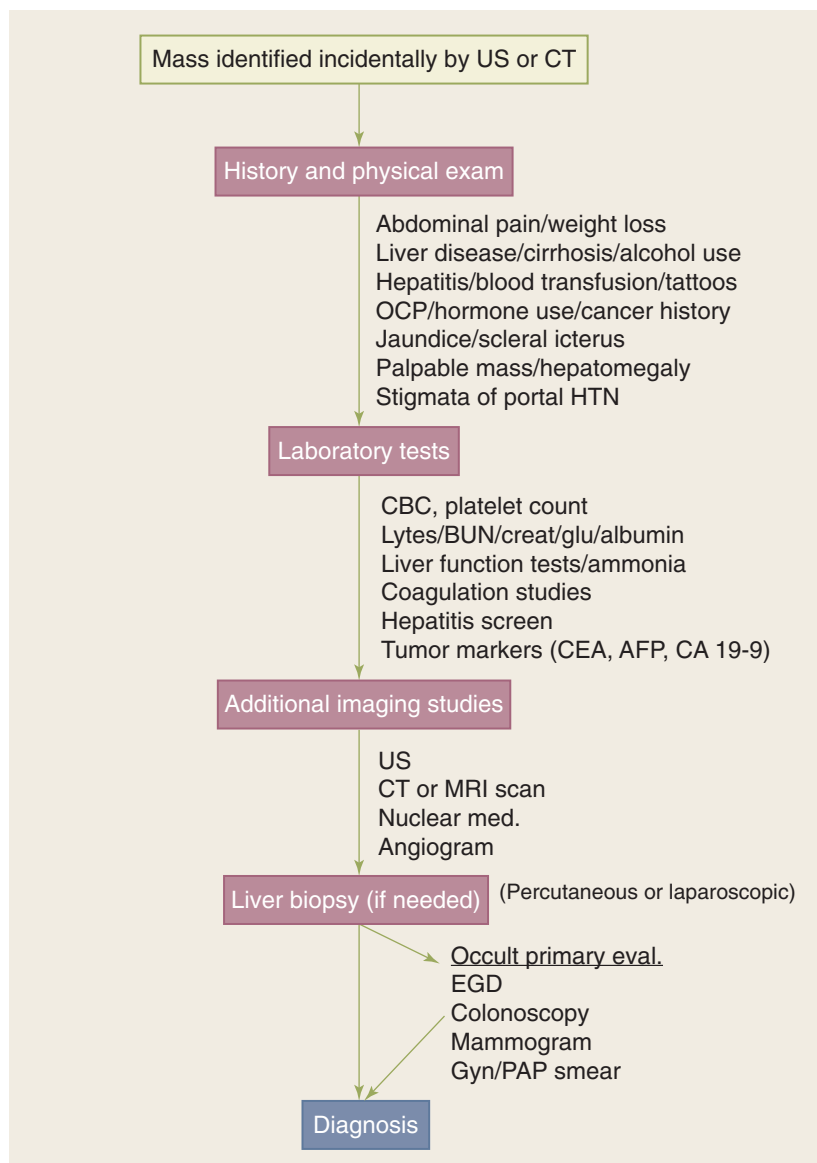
Algorithm for diagnostic workup of an incidental liver lesion. The evaluation includes history and physical examination, blood work, imaging studies, and liver biopsy (if needed). AFP = α -fetoprotein; BUN = blood urea nitrogen; CA 19-9 = cancer antigen 19-9; CBC = complete blood count; CEA = carcinoembryonic antigen; creat = creatinine; CT = computed tomography; EGD = esophagogastroduodenoscopy; glu = glucose; Gyn = gynecologic; HTN = hypertension; MRI = magnetic resonance imaging; OCP = oral contraceptive pill; PAP = Papanicolaou; US = ultrasound.
